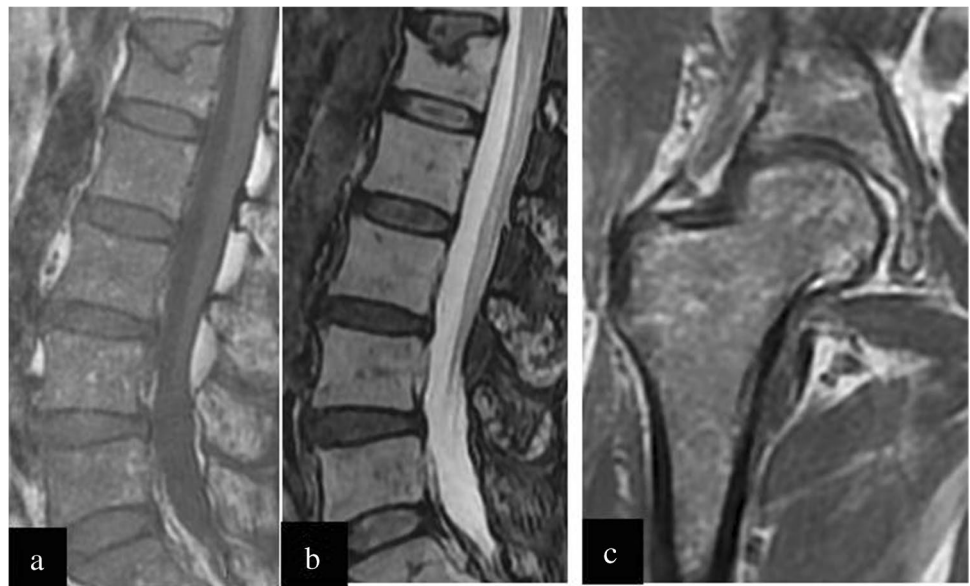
A 59-year-old man with SD IIIA (ISS 1) MM and focal pattern of marrow involvement at MRI. a Sagittal T1 SE image of the lumbar spine demonstrates a focal low signal intensity marrow lesion in L5 (arrow). b Water-only Dixon T2 Dixon image demonstrates high signal intensity in the L5 lesion. Bone marrow of other lumbar vertebral bodies is within normal limits. Blind iliac crest biopsy demonstrated low tumor burden with 9% abnormal plasma cells. c Coronal T1 SE image of the right femur shows a normal marrow pattern with fatty marrow in femoral head and greater trochanter
